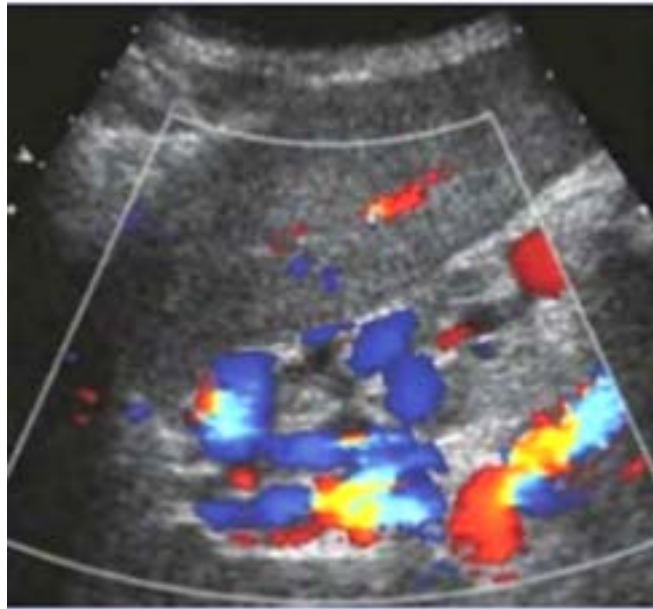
Doppler US, showing in the longitudinal view of the left liver lobe, the gastroesophageal collaterals close to the diaphragm
